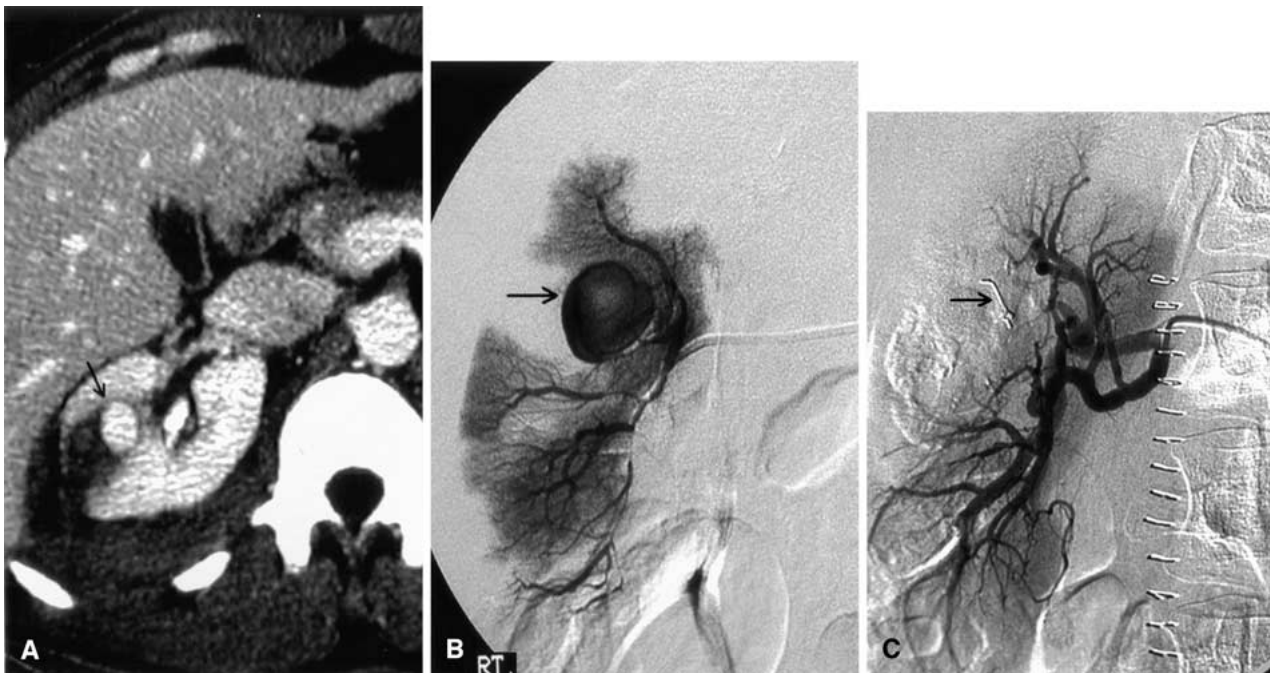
A 37-year-old man with a stab wound. A Axial CT scan shows pooling of contrast in an area of laceration in the right kidney, suggesting traumatic pseudoaneurysm (arrow). B Right renal arteriogram shows a large pseudoaneurysm
